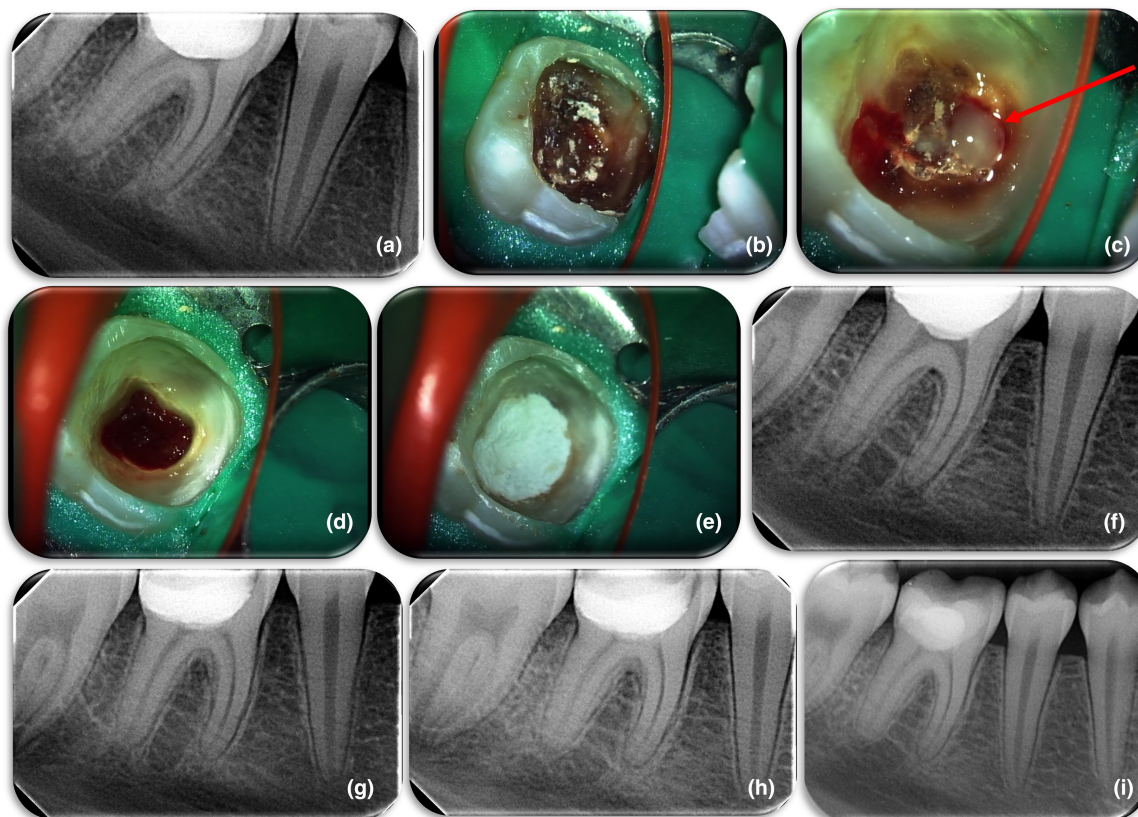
(a) Initial radiograph of a mature first mandibular molar of a 16-year-old patient with periapical lesion in both roots, (b) initial clinical figure of the tooth and caries after appropriate isolation, (c) pus drainage after communication with pulp chamber during caries removal, (d) complete caries removal and adequate control of bleeding after pulpotomy, (e) appropriate placement of MTA Angelus over the remaining coronal pulp tissue, (f) postoperative radiograph. (g) 6-month recall radiograph. Note the inadequate margins of the permanent coronal restoration (h). 12-month recall radiograph. The inadequate restoration has not been replaced (i). 30-month recall radiograph, no lesions are present and complete periapical healing has occurred, fortunately, a new sufficient restoration is in place.
